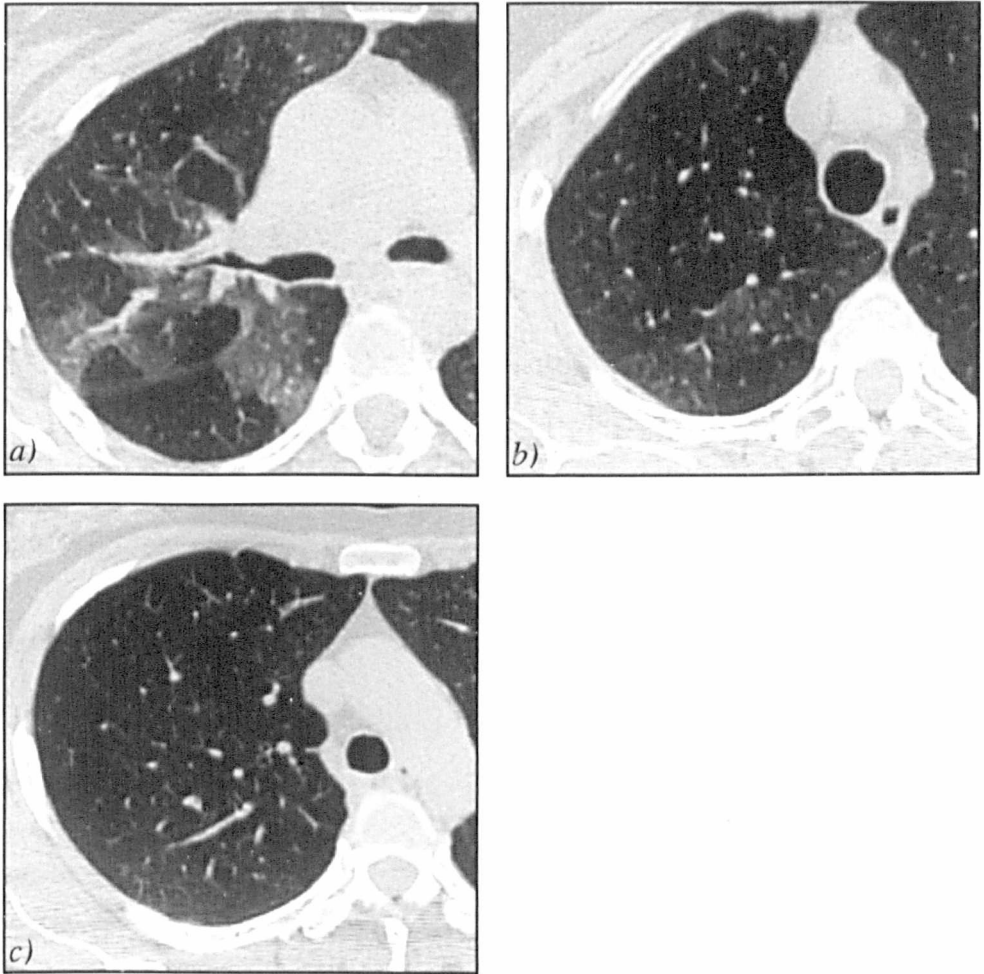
Three examples of CT scans of lungs with constrictive obliterative bronchiolitis of different severity. *a)* Severe case where the hypo-attenuated areas can be easily detected. *b)* Mild case where the intensity differences are more subtle. *c)* Pre-symptomatic case where the identification of the areas of hypo-attenuation is difficult, even for an experienced observer
